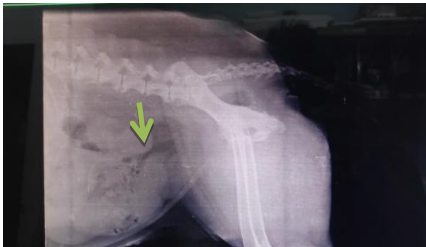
Radiograph of abdomen showing opaque distended uterine shadow in the lower abdomen
